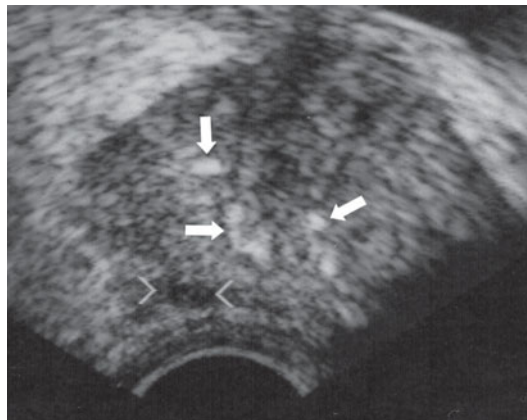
Ultrasonography. Transrectal approach. The structure of the prostate appears coarser than normal, with numerous small calcifications (*arrows*). In the peripheral zone two *landmarks* indicate the presence of a focal lesion, which after US-guided biopsy proved to be adenocarcinoma
